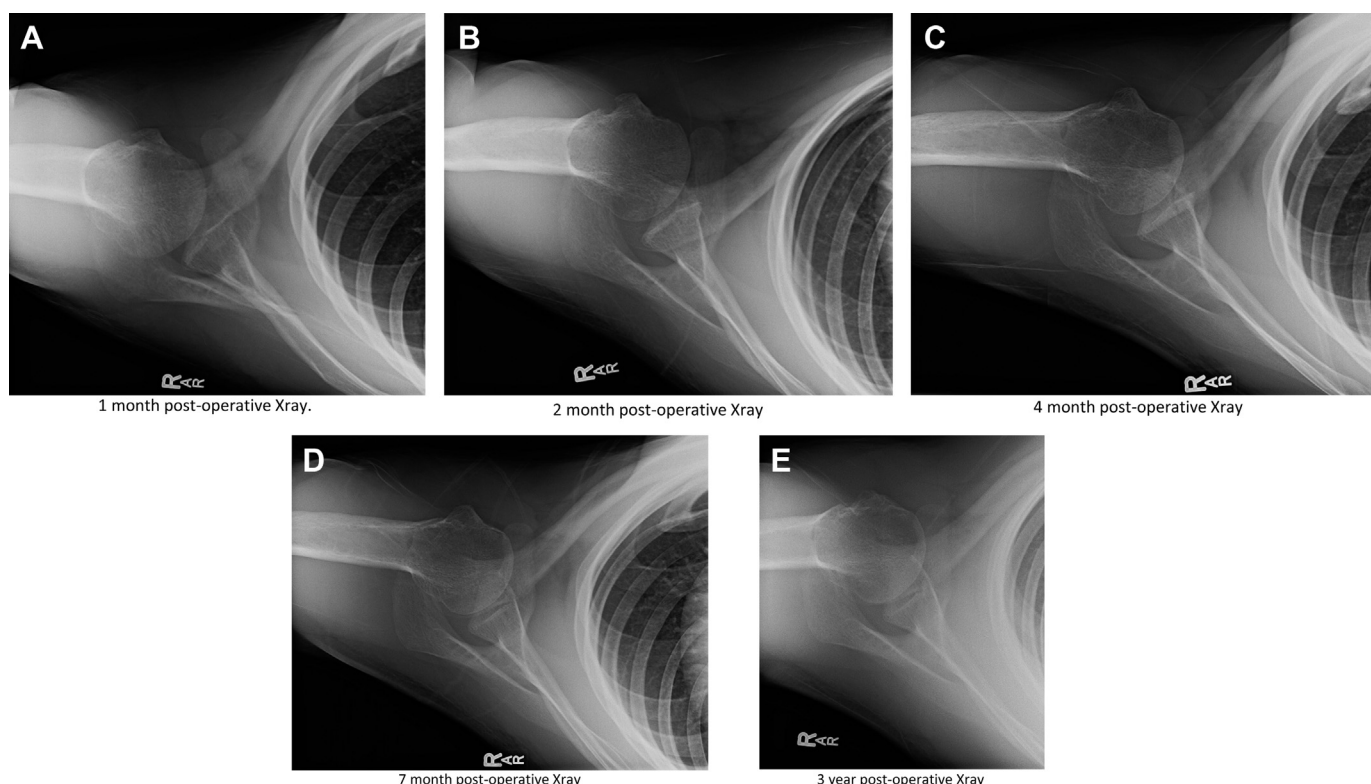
Plain axillary radiographs of a patient demonstrating osteotomy and allograft healing from (A) 1 month postoperatively, (B) 2 months postoperatively, (C) 4 months postoperatively, (D) 7 months postoperatively, and (E) 3 years postoperatively.
